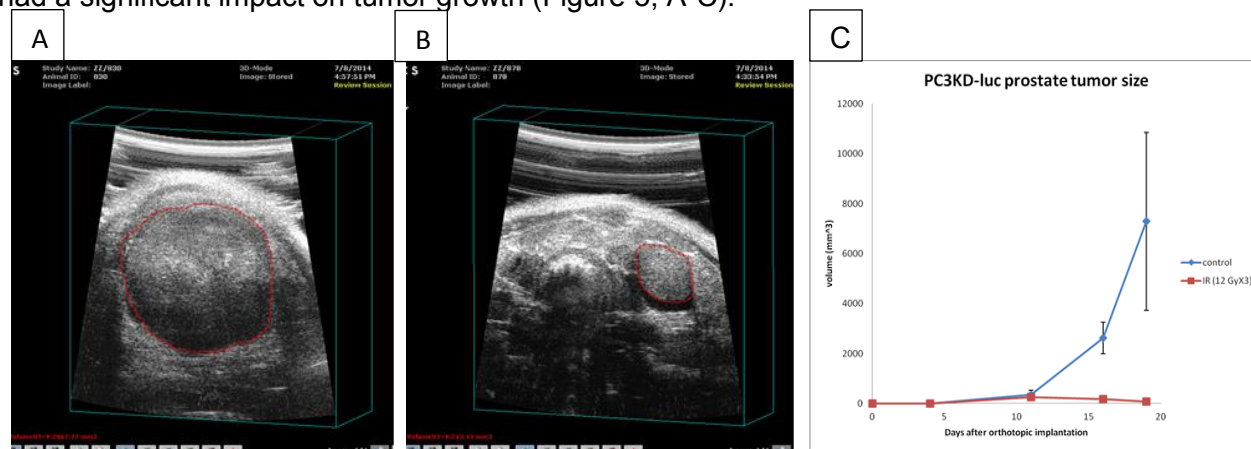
Prostate tumors measured by ultrasound. A. Control and B. Irradiation. C. Tumor progression curve.
